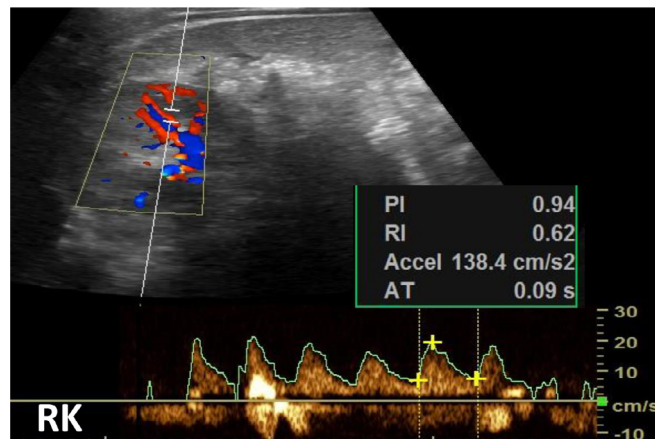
Follow-up color-Doppler US (CD-US) post-angioplasty: a resistive index value within the normal limits (RI 0.62) as well as the acceleration gradient. No more evidence of “parvus and tardus” pulsus waveform.
